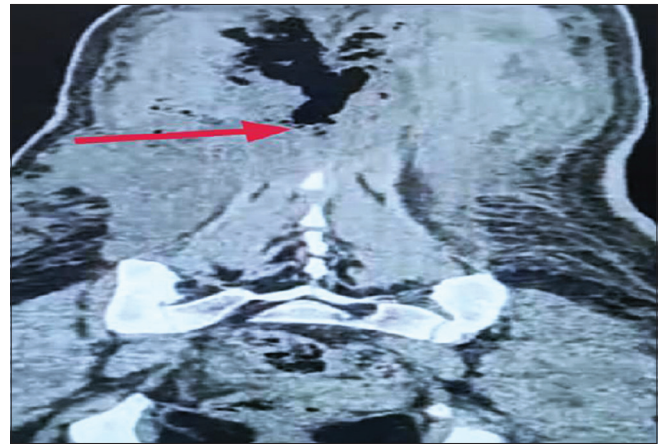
Non-contrast computed tomography abdomen axial image scan shows gas in the retrovertebral space (red arrow)
